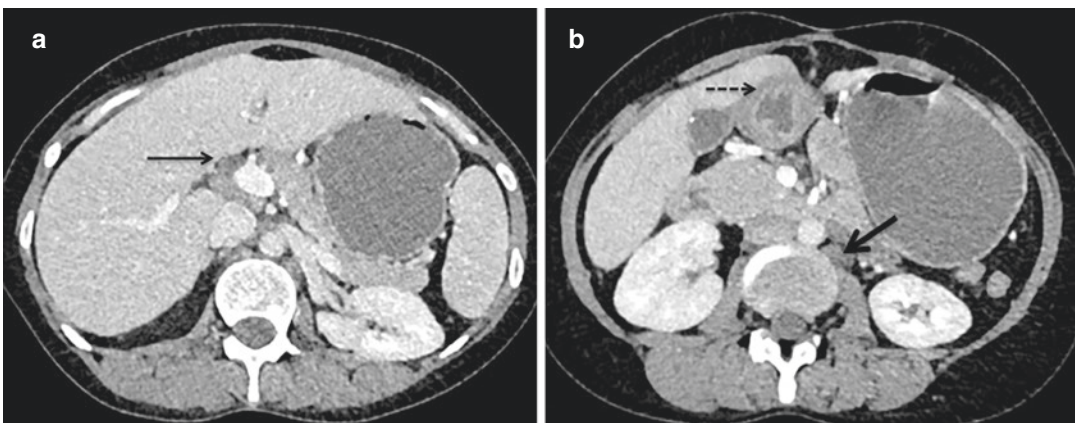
24-year-old woman, a known case of gastrointestinal tuberculosis who previously underwent operation for small bowel obstruction, now presented with recurrent upper abdominal pain. (a) Axial contrast-enhanced CT image shows necrotic periportal lymph nodes (thin solid
